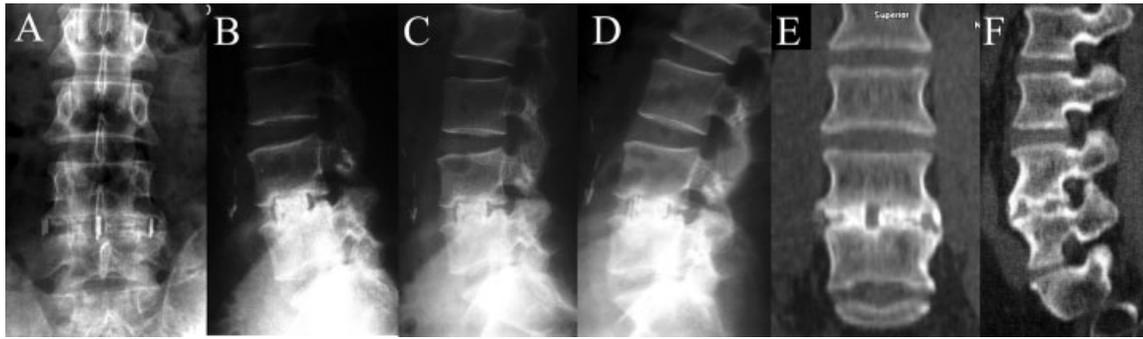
Case 1. Fusion in a silicate calcium phosphate (SiCaP) case at 12-month follow-up. (A) Anteroposterior x-ray. (B) Flexion lateral x-ray. (C) Orthostatic lateral x-ray. (D) Extension lateral x-ray. (E) Coronal view of a computed tomography (CT) scan. (F) Sagittal view of a CT scan.
